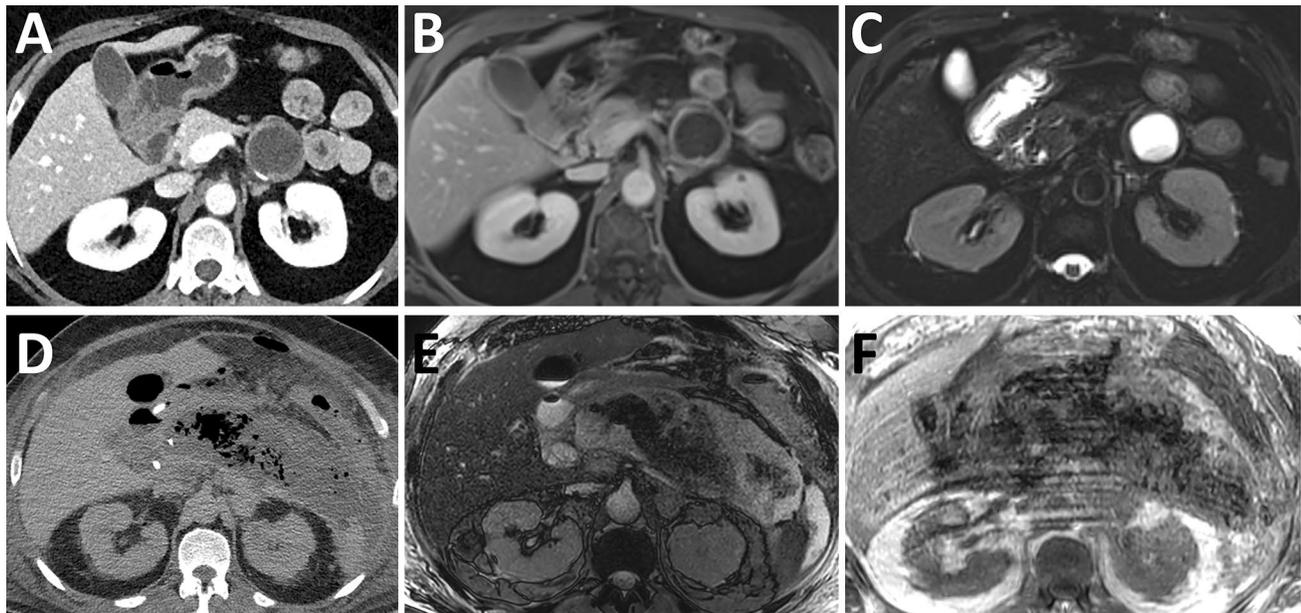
MRI in addition to CECT can improve characterization of complicated pancreatic fluid collections. Top row, 60-year-old female with history of interstitial edematous AP. a Axial CECT 7 months after symptom onset shows a 3.8×3.8 cm cystic lesion in the tail of the pancreas with thin peripheral calcification posteriorly. b T1-weighted and c T2-weighted axial MR images of the abdomen with and without contrast, respectively, confirm that the lesion is a pancreatic pseudocyst. Axial T1 post gadolinium image reveals a well-defined wall and axial T2 weighted image demonstrates a fairly uniform hyperintense lesion within the pancreatic tail with minimal amount of dependent debris. Bottom row, 64-year-old man with acute
